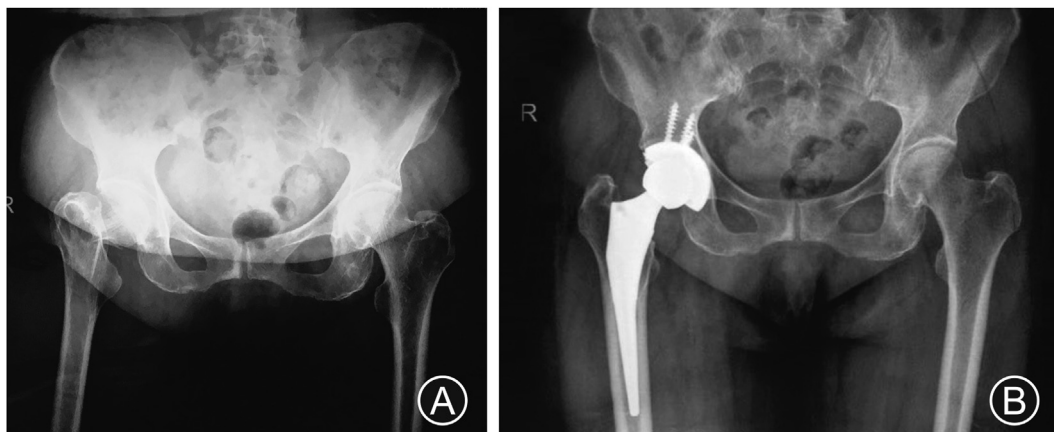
(A) Right femoral neck fracture after a fall. (B) Radiography of the right hip total arthroplasty.
